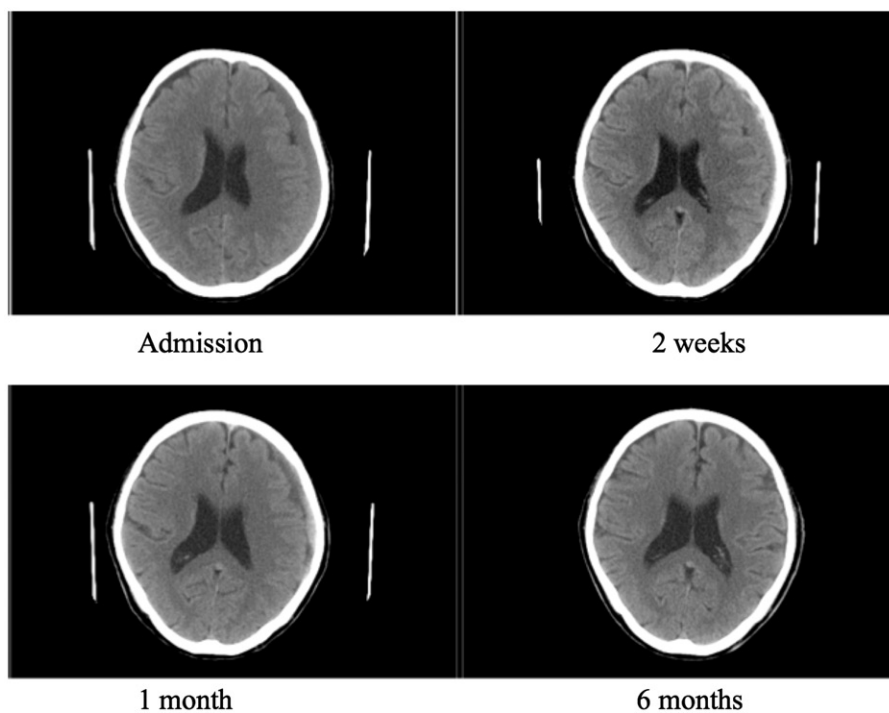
CT brain scan of a 79-year-old lady presented with poor memory.
